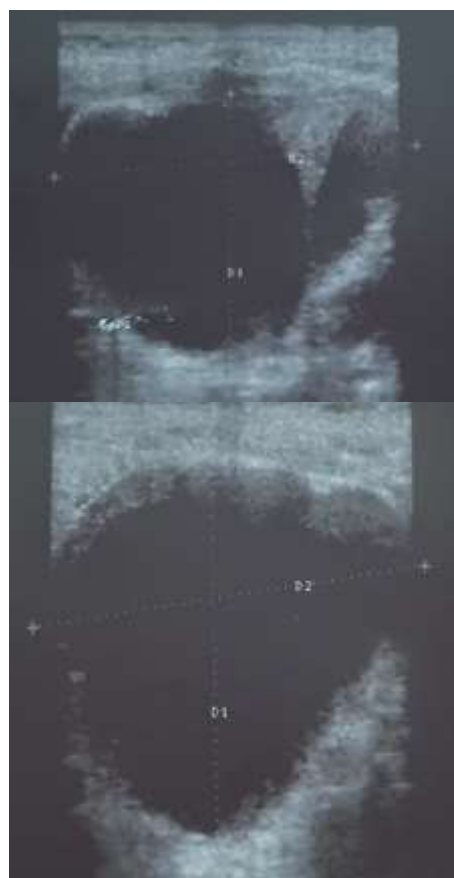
Thyroid ultrasound: an inhomogeneous hypoechoic lesion on the posterior side of the left lobe
